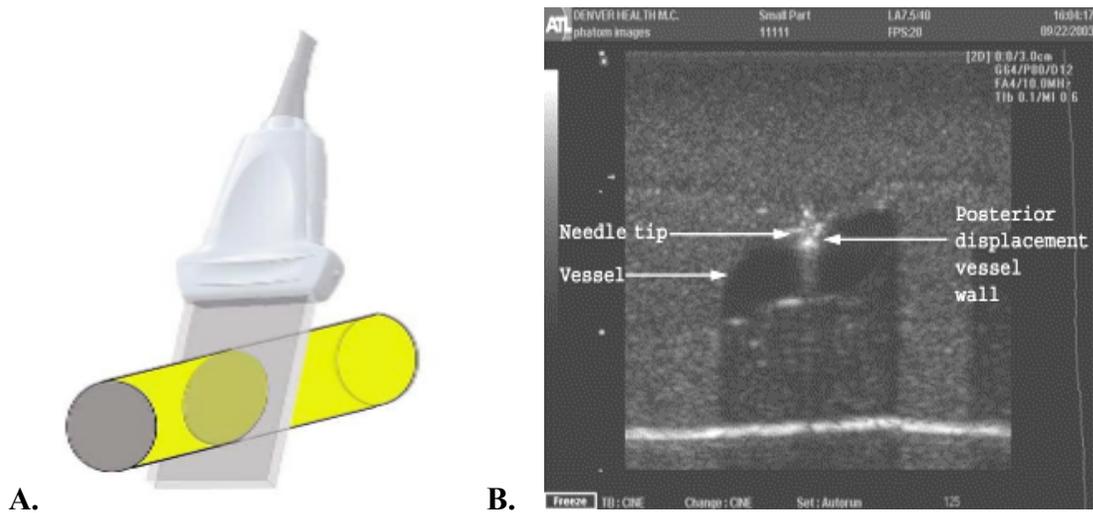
When the vessel is centered on the ultrasound screen (Image B) its anatomical position will run under the center of the probe (Image A).
